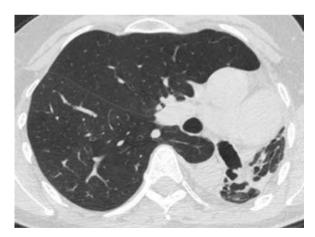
High resolution computed tomography of the chest in a 52 year-old female with dyspnoea.
